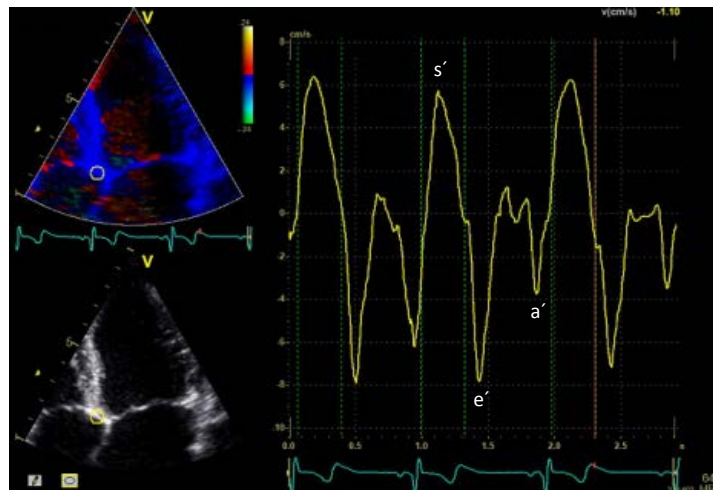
Color-coded TDI echocardiography in 4-chamber view showing myocardial velocities. Peaks denote  $s'$  (systole),  $e'$  (early diastole), and  $a'$  (late diastole) in cm/sec.
